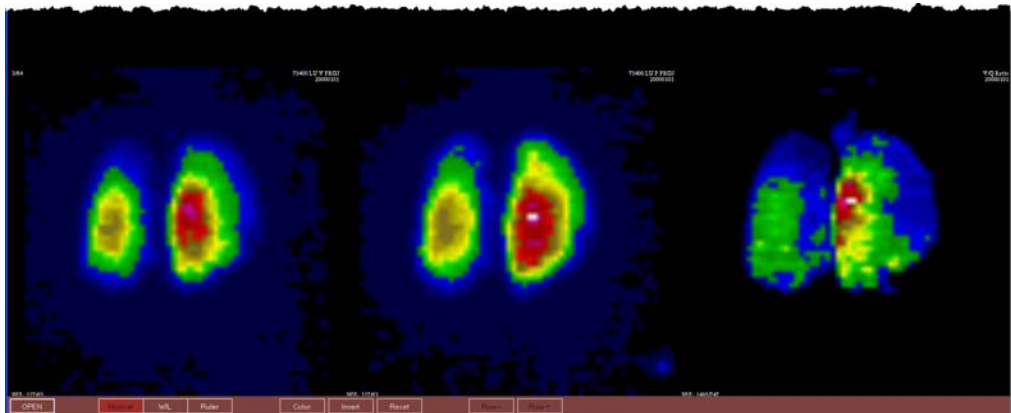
LungSPECT: M.I.P.s of ventilation and perfusion, and a V/Pq rotating cine.
